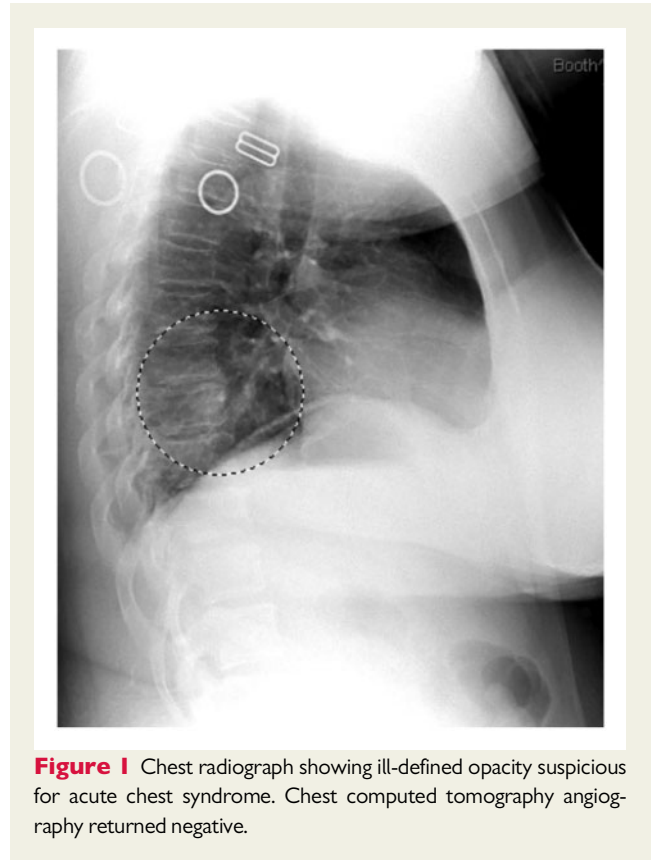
Chest radiograph showing ill-defined opacity suspicious for acute chest syndrome. Chest computed tomography angiography returned negative.
